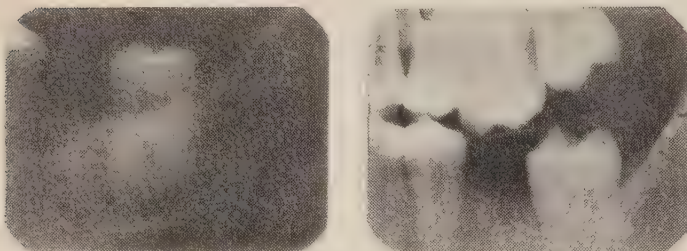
Radiographs taken in August 1964.
